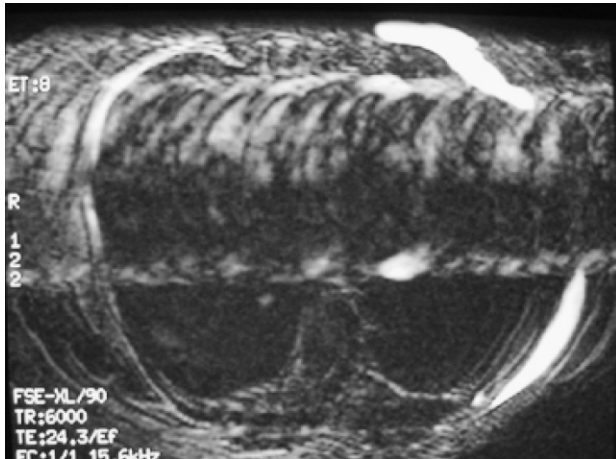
The most distal MRI scan at a level just superior to the iliac crest showing the extent of silicone spread around the left hemithorax.
